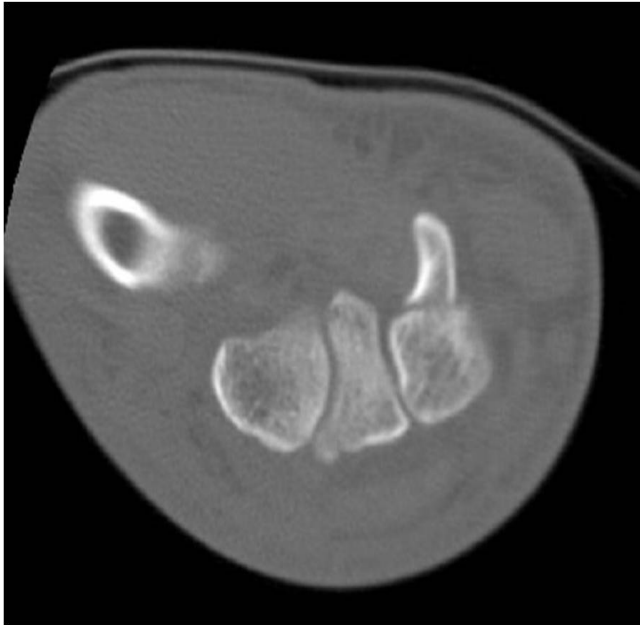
Axial (A) and sagittal (B) computed tomography images of a fracture of the base of the hook of the hamate.
